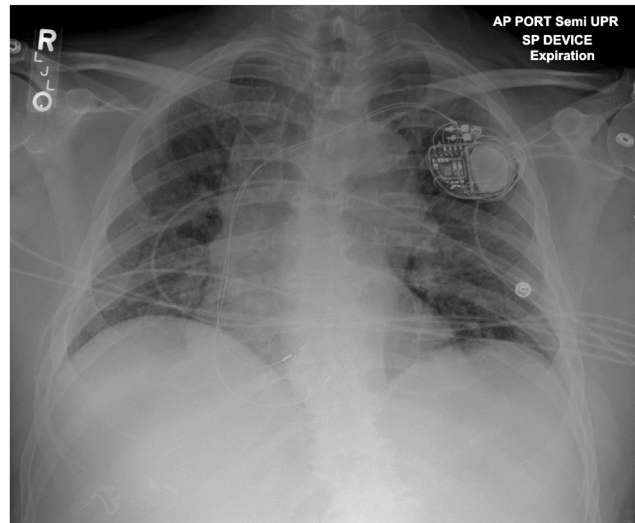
Postoperative chest radiograph with a 3830 lead (Medtronic, Minneapolis, MN) at the left bundle position and low right atrial septum.
